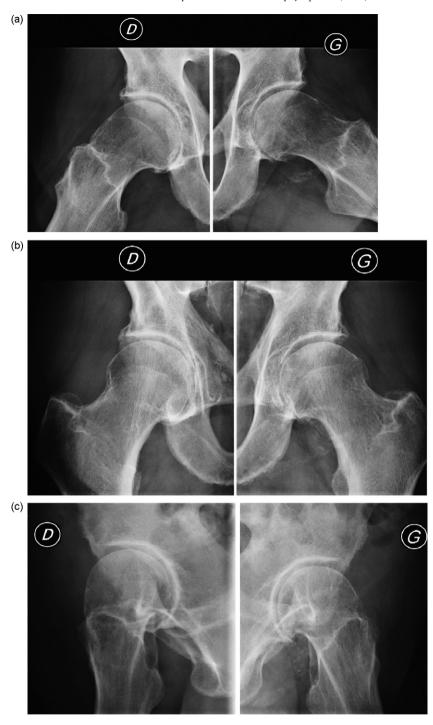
a-c: anteroposterior and sagittal radiographs of the hip. Case 2.
